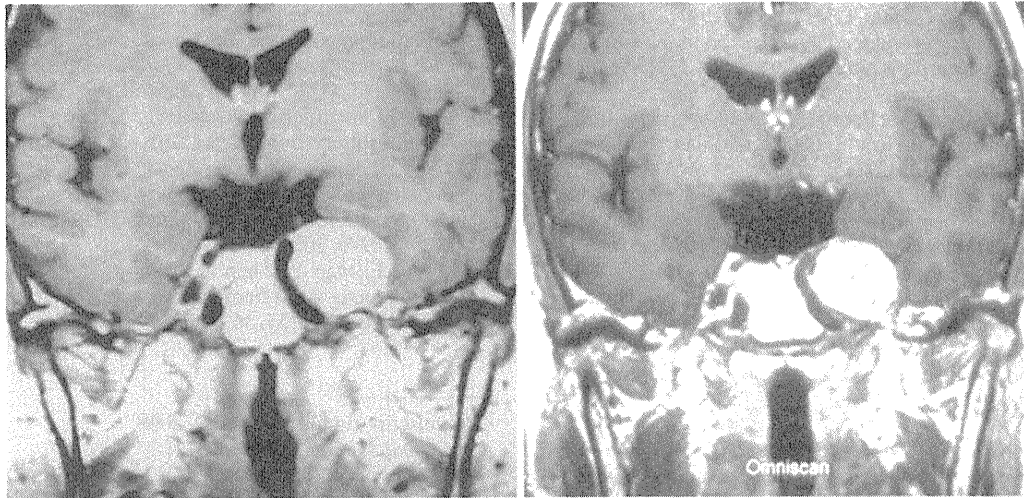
Case 16. Sequential contrast-enhanced T1-weighted coronal MR images obtained before (left) and 64 months after GKS (right).
